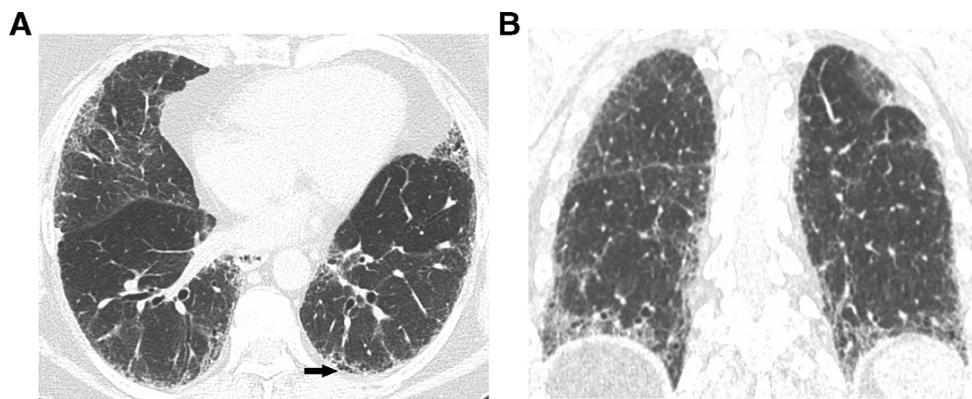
A 65-year-old female with rheumatoid arthritis and UIP. Axial (A) and coronal reformatted (B) HRCT images show subpleural and basal predominant reticulation with minimal honeycombing (arrow). UIP, usual interstitial pneumonia.
